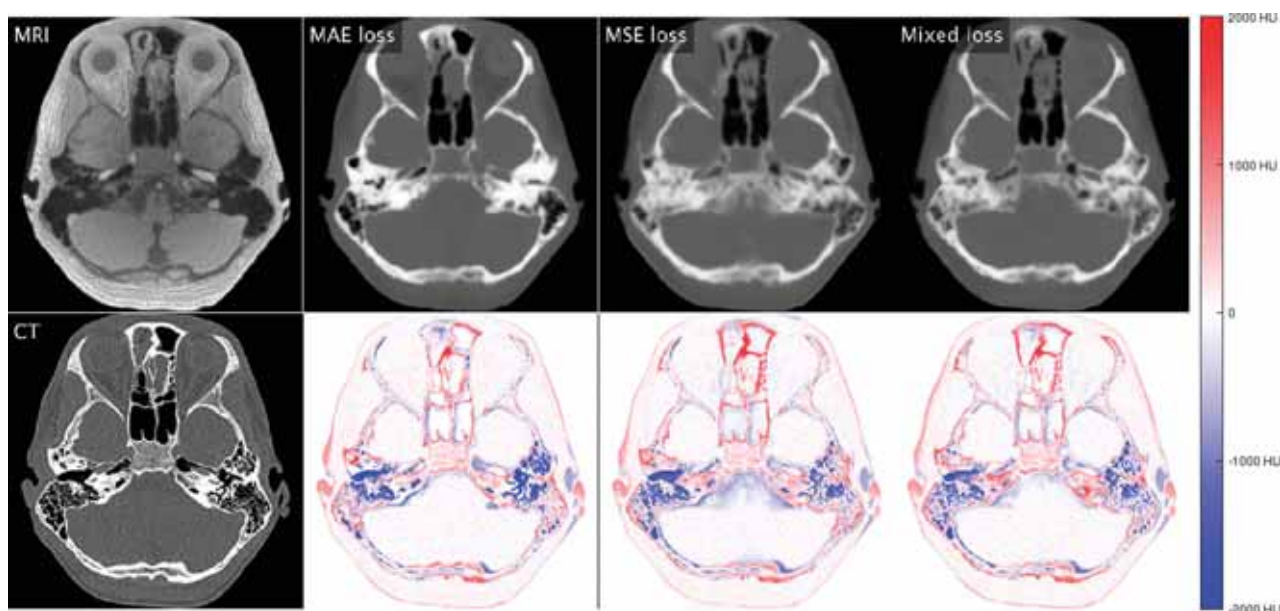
Comparison of different loss functions using a Light_U-Net model. The first column shows real MR imaging and real CT. Subsequent columns show synthetic CTs generated when using a loss function based on MAE, MSE, and a mixed combination, as well as pixel-wise difference maps between synthetic CT and real CT. Red indicates that synthetic CT is darker than real CT; blue, synthetic CT is brighter than real CT (Refer online version for colors).
